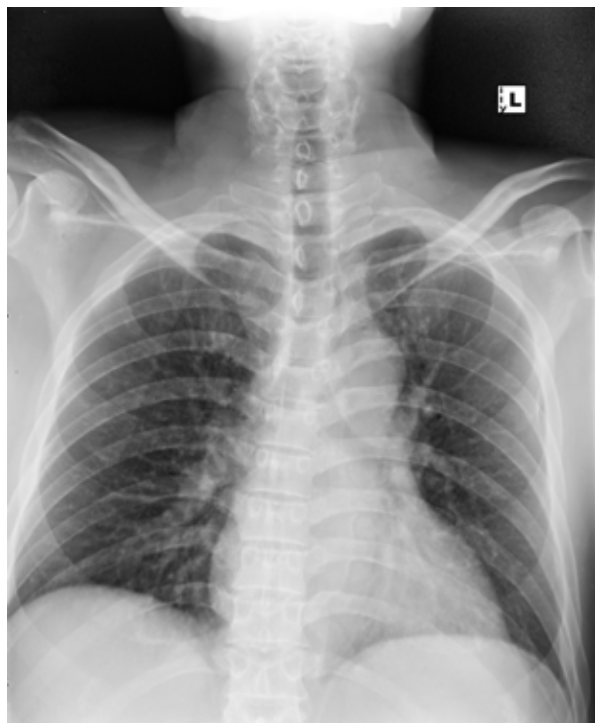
Chest radiograph on admission showing borderline cardiomegaly, no active lung lesion in both lung fields.
